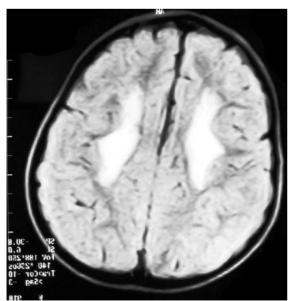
T2-weighted images reveal increased signal intensity in the cerebral white matter.
